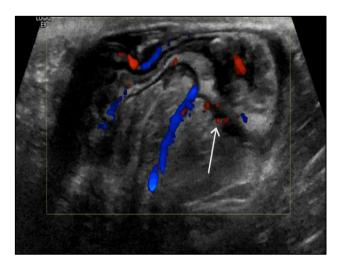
Doppler ultrasound. Preoperative abdominal ultrasound showing an umbilical defect with a small bowel loop as content (arrow), with adequate color Doppler signal.
